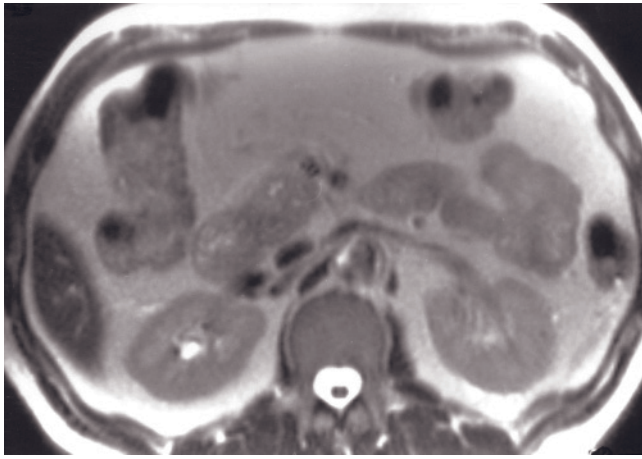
Staging pancreatic cancer—vessel involvement. Coronal T2-weighted SS-ETSE (a), angled coronal MRCP (b), immediate postgadolinium T1-weighted SGE (c), and 90-s postgadolinium fat-suppressed SGE (d) images. A 5-cm tumor arises from the pancreatic head and obstructs the CBD and pancreatic duct (arrow, b), which is well shown on the MRCP image (b). The interstitial-phase gadolinium-enhanced image (d) shows a nonocclusive thrombus in the superior mesenteric vein (arrow, d) and tumor stranding around both superior mesenteric vessels. Coronal (e) and transverse (f) T2-weighted SS-ETSE and immediate postgadolinium T1-weighted SGE (g) images in a second patient with pancreatic head adenocarcinoma. Note atrophy of the pancreatic body and tail with dilatation of main pancreatic duct. Ductal dilations of the CBD (arrow, e) and pancreatic duct (arrow, f) are best shown on single shot T2-weighted images (including MRCP). The tumor is best shown on immediate postgadolinium images (g). Encased superior mesenteric artery is shown (arrow, g).
